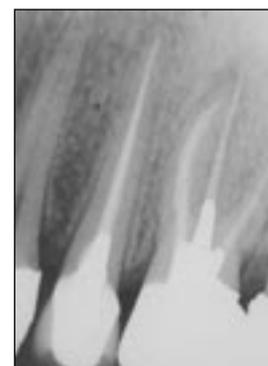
Periapical radiograph taken at 6 months review appointment showing partial resolution of periapical radiolucencies associated with 25 and 26.
